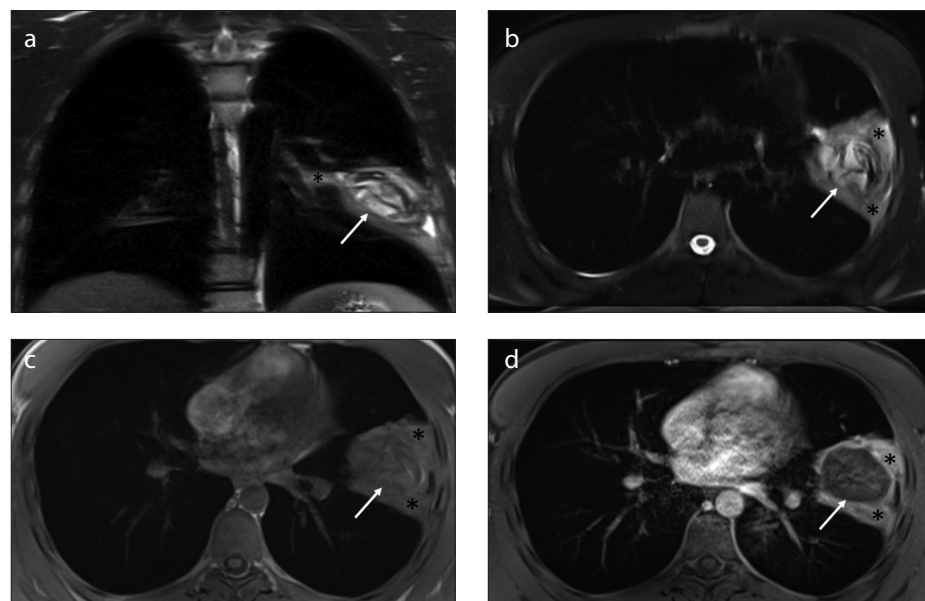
a-d. A 15-year-old male with a ruptured hydatid cyst in the left lower lobe anteromedial segment. Coronal T2-weighted (a), axial T2-weighted fat-suppressed (b), and axial T1-weighted (c) images reveal the hydatid cyst (white arrow) and intense inflammation secondary to rupture (black asterisk). Axial postcontrast-enhanced image (d) reveals no contrast enhancement in the hydatid cyst lesion (white arrow) and distinct contrast enhancement in the inflammation secondary to rupture (black asterisk).
